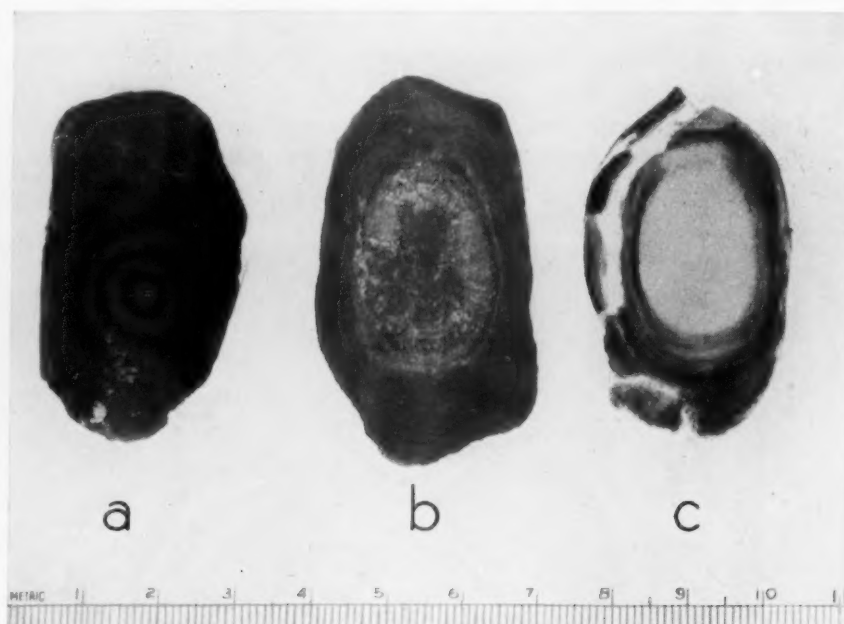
Case 6: (a) Photograph of exterior and (b) of cut surface of stone. (c) Roentgenogram of slice. Central portion is a cholesterol stone. Dark periphery consists of pigment, calcium carbonate, and cholesterol.
